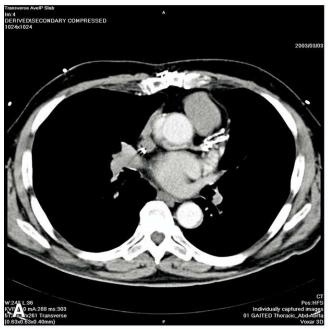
Axial CTA (A) and volume rendered display (B) of the chest following gadolinium administration with a saline flush in a patient with impaired renal function scheduled to undergo redo coronary artery bypass graft surgery. Saline enables maximal utilization of a triple-dose (60 mL) bolus of gadolinium, which provides sufficient radio-opaque intravascular contrast for a short 16-detector-row CT scan. This approach enables obtaining similar image information before redo surgery as an iodine-enhanced scan (C) in a comparable patient. (Color version of figure is available online.)
